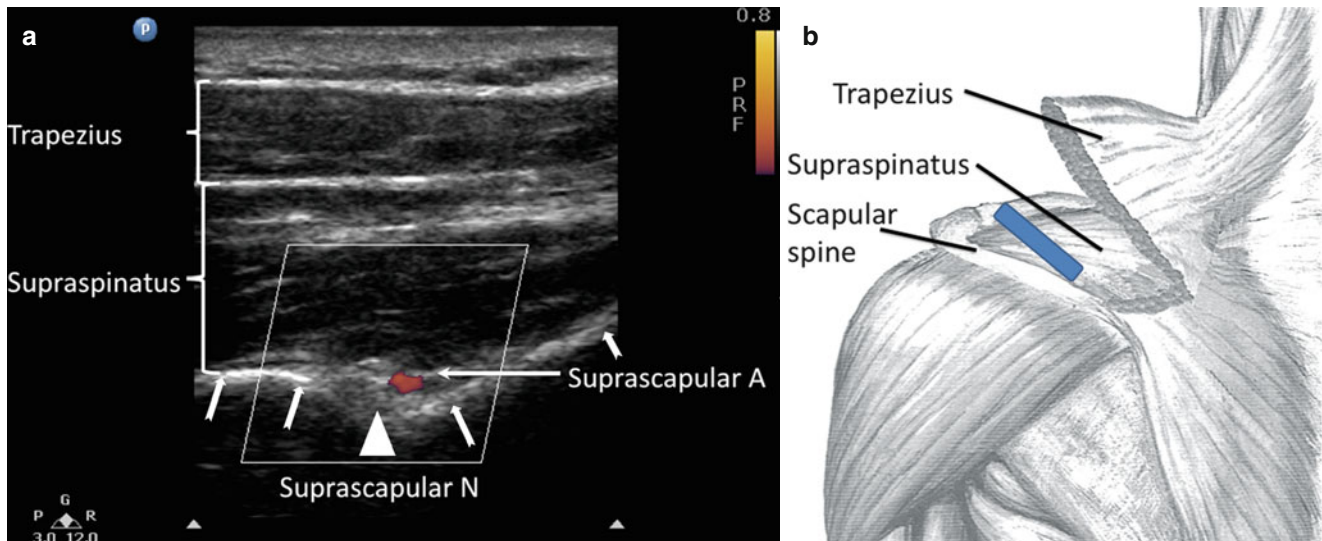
(a) Ultrasonographic image of the suprascapular nerve on the floor of the scapular spine between suprascapular notch and spinoglenoid notch. Both suprascapular nerve and artery run underneath the fascia of supraspinatus muscle. Suprascapular A and N indicate suprascapular artery and nerve. *Bold arrows* outline the floor of the scapula fossa. (b) Approximate position of the ultrasound probe (*dark rectangle*). The patient can be in sitting or in prone position. Ultrasound
